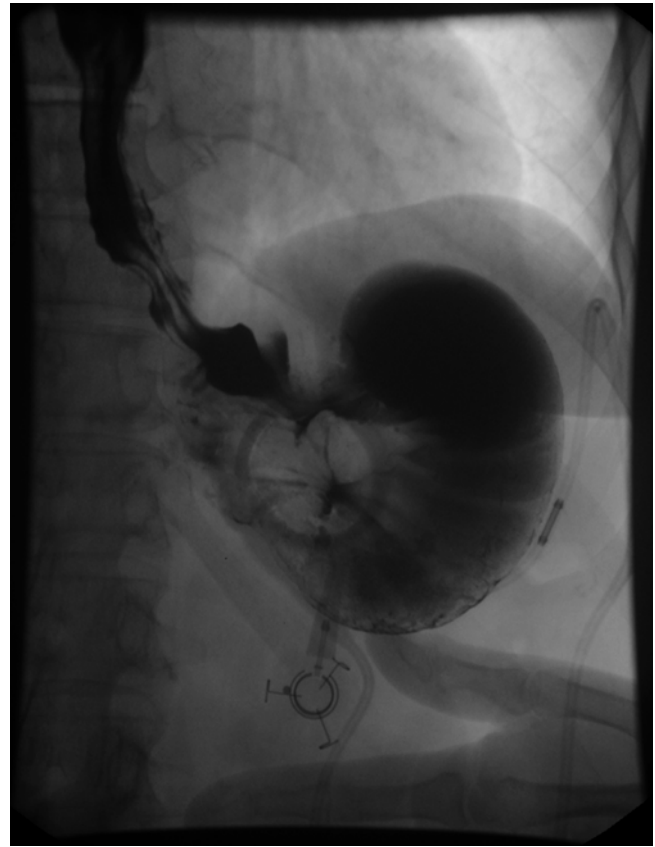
Acute anterior band slippage resulting in complete obstruction to flow of X-ray contrast
